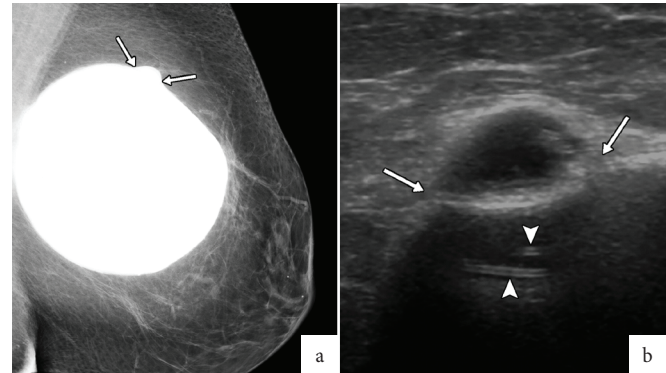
A. Mammogram showing an abnormal implant contour (arrows). B. Ultrasound confirms an intracapsular rupture with silicone leak (arrows) and a displaced shell depicted as parallel echogenic lines (arrowheads).
